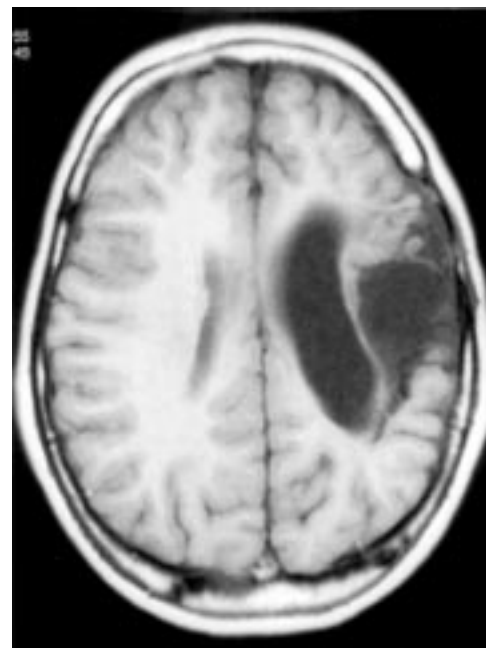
Magnetic resonance imaging in a boy with no genetic risk factor for familial thrombophilia: left parieto-temporal porencephaly is shown.
